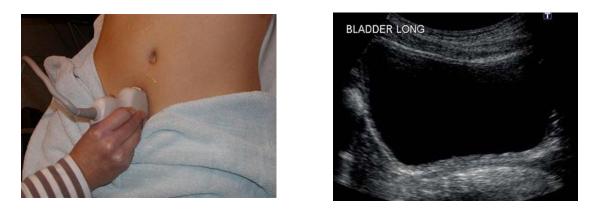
Represent probe position of longitudinal scan (left) and ultrasonic image of section (right) [Ultrasoundpadeia 2014]
